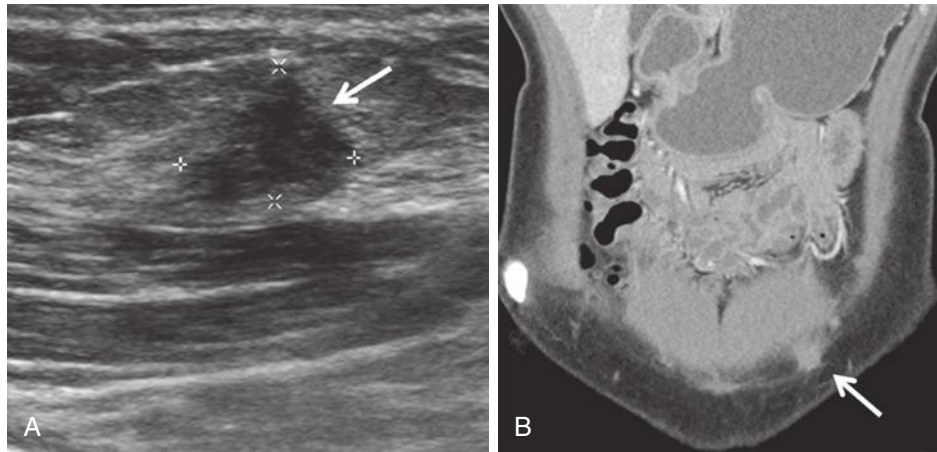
Abdominal wall endometriotic implant. A, Hypoechoic, irregularly margined solid nodule (*arrow* and *calipers*) in the subcutaneous soft tissues at the anterior abdominal wall, ventral to the rectus muscle near the surgical scar. The patient, with history of open myomectomy 2 years prior, has a palpable lump. B, Coronal computed tomography image demonstrates the nodule (*arrow*) in the subcutaneous soft tissues, corresponding to the finding on ultrasound imaging.
